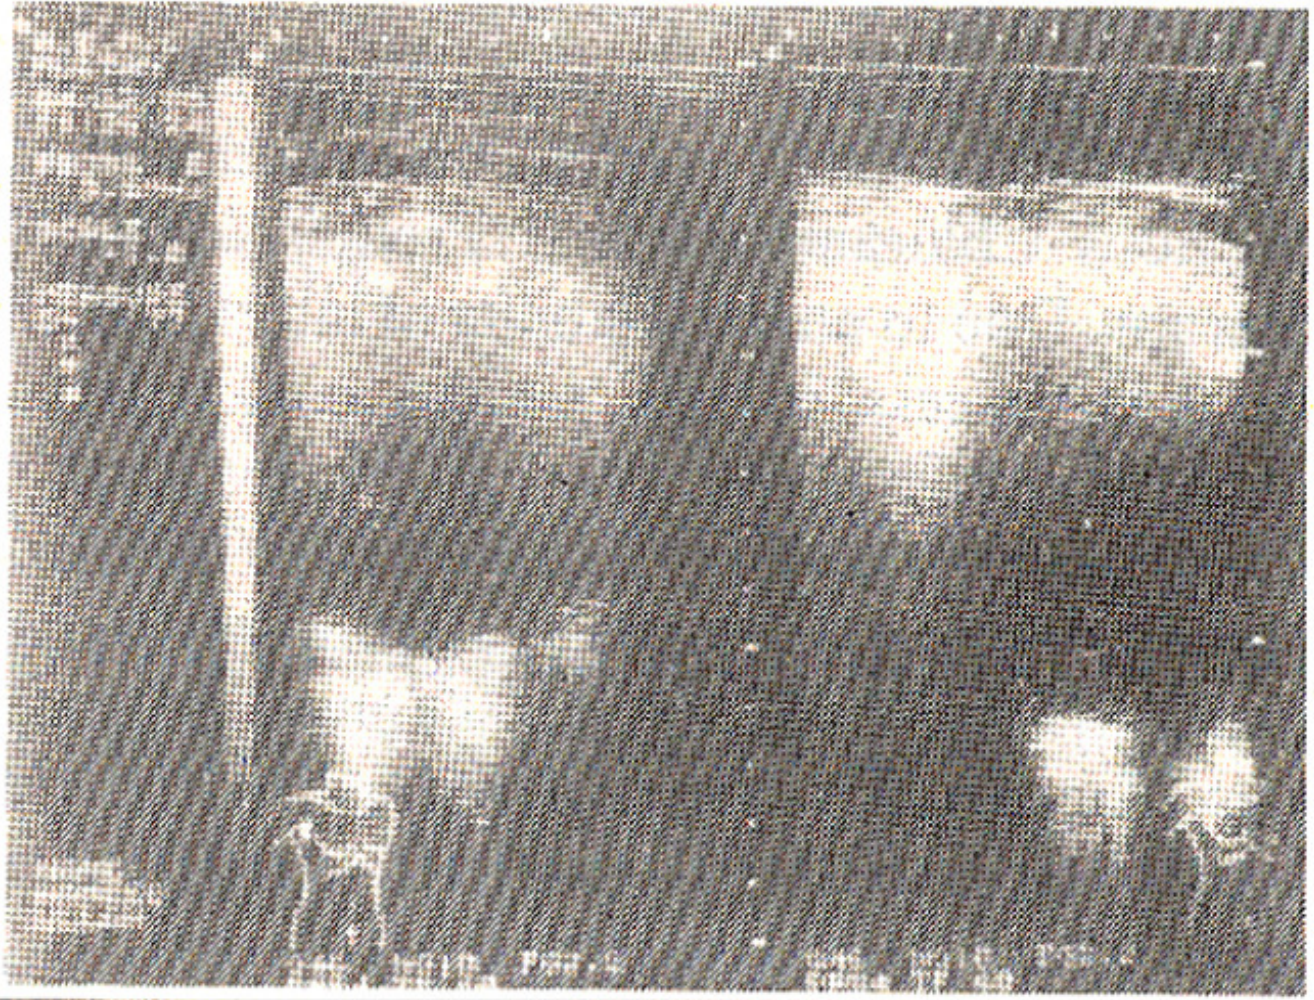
Ultrasound of the Right upper chest, viewed through the axilla, showing a rounded hypoechoic lesion with a strong back wall and posterior enhancement.
